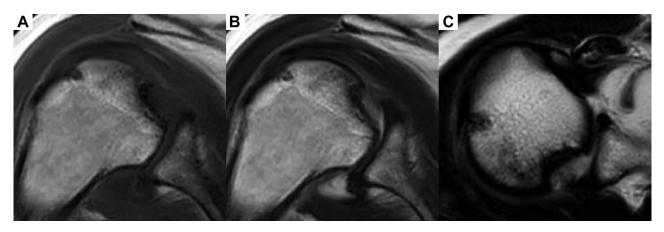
Preoperative magnetic resonance imaging of the right shoulder. (A) Oblique coronal T1-weighted image of the right shoulder. (B) Oblique coronal T2-weighted image of the right shoulder. (C) Axial T2-weighted image of the right shoulder.
